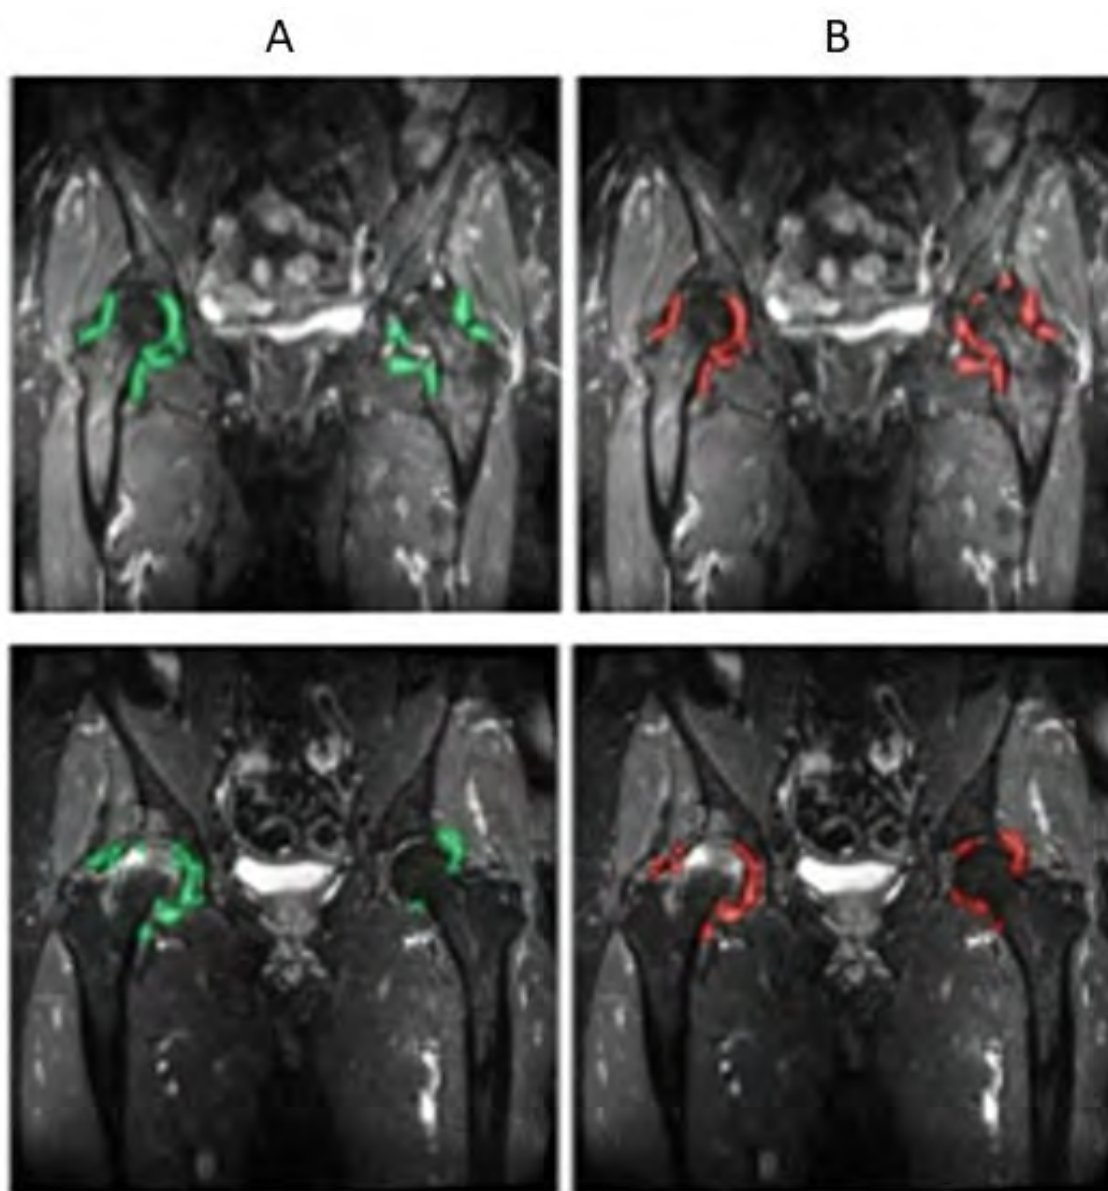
Regions of joint fluid detected by human readers (green, column A) and AI (red, column B) overlain on the original STIR MRI slice from 2 different patients with OA.
